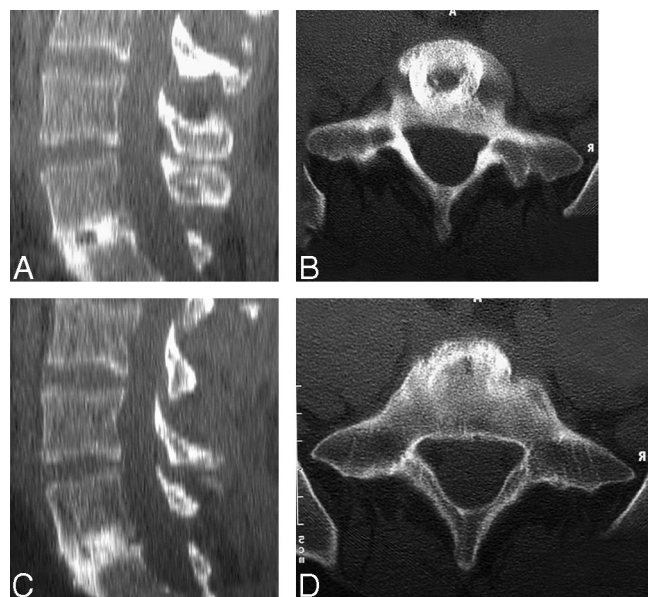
CT reveals prolonged preservation of allograft with the use of autogenous ICBG *versus* rhBMP-2. Scans of FRA and ICBG at 12 months are shown in A and B, and scans of FRA and rhBMP-2 at 12 months are shown in C and D.
